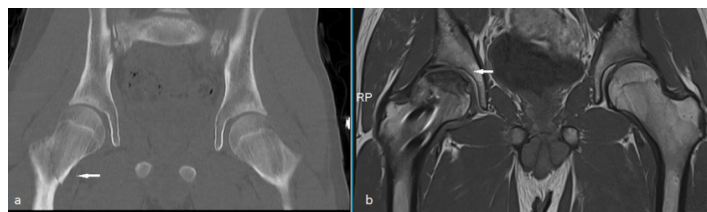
a) On the coronal CT image, the intertrochanteric fracture is seen on the right b) No fracture line is observed in the coronal T1 WI one year later. Irregularity, volume loss, sclerosis, and edema are seen in proximal femoral epiphysis compatible with avascular necrosis
